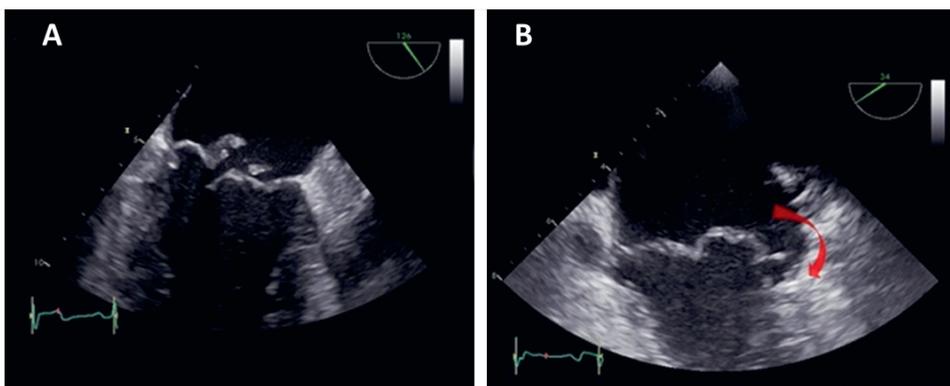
Transoesophageal echocardiographic views of in panel A: a patient with fibroelastic deficiency (FED) with flail of the posterior mitral valve leaflet and in panel B a patient with Barlow's disease (BD) with bi-leaflet mitral valve billowing and systolic mitral annular disjunction (red arrow).
